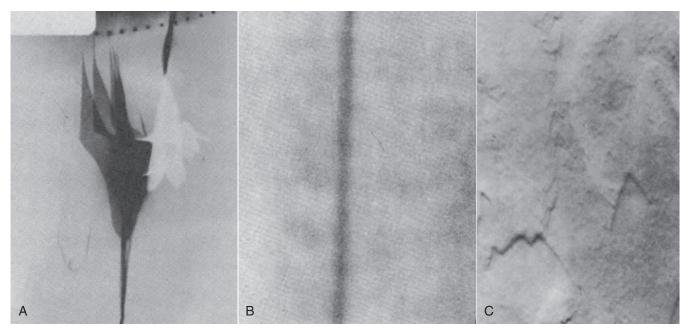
Radiographs of mistreated protective aprons showing bunching of the lead (A) from folding and tearing, a low-density area in a new apron (B), and cracking patterns in an apron (C). (Courtesy Sharon Glaze, Baylor College of Medicine.)
